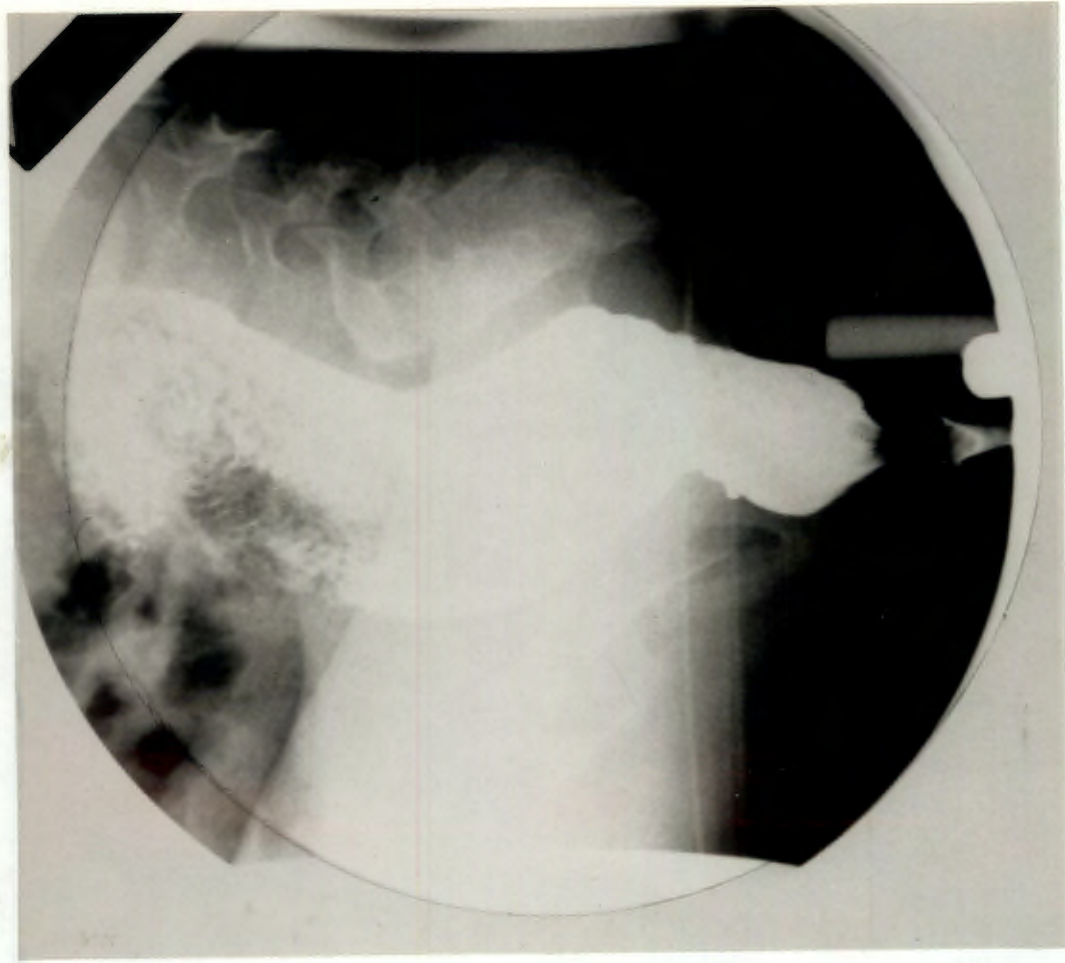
Radiograph taken during video-proctography and evacuation of rectum by patient with obstructive symptoms post Hirschsprung's surgery (note lack of features of achalasia)
